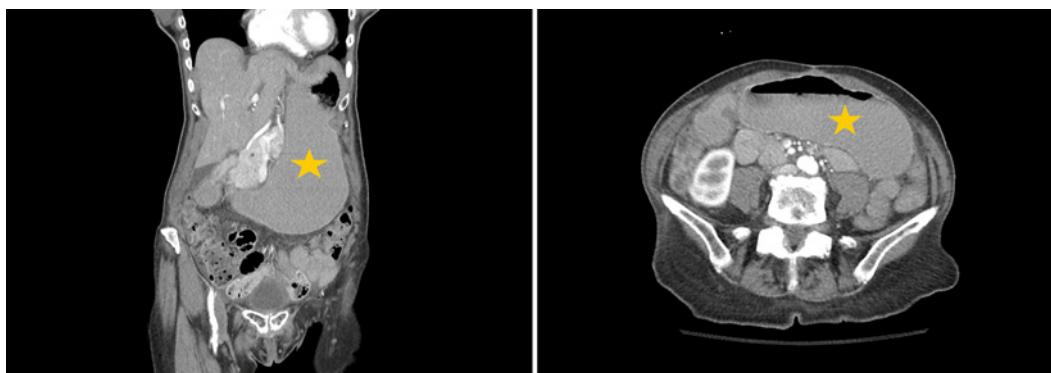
A contrast-enhanced CT scan of the abdomen and pelvis (coronal and axial views) showing marked gastric distension with some mild inflammation around the antroduodenal junction.
